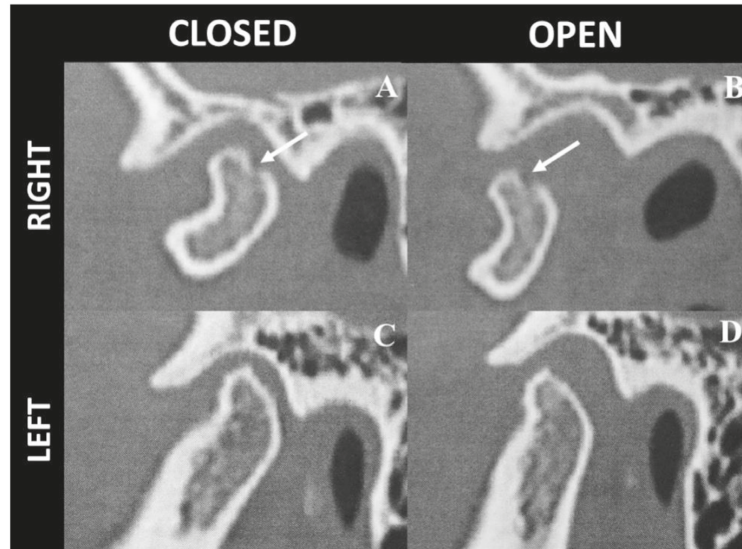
Sagittal multidetector computed tomography images of temporomandibular joints. (A) Right TMJ in closed-mouth position demonstrating cortical discontinuity (white arrow) indicative of degenerative changes. (B) Right TMJ in open-mouth position showing persistent cortical irregularity (white arrow). (C) Left TMJ in closed-mouth position with intact cortical bone. (D) Left TMJ in open-mouth position showing normal morphology. All images are displayed in bone window settings.
